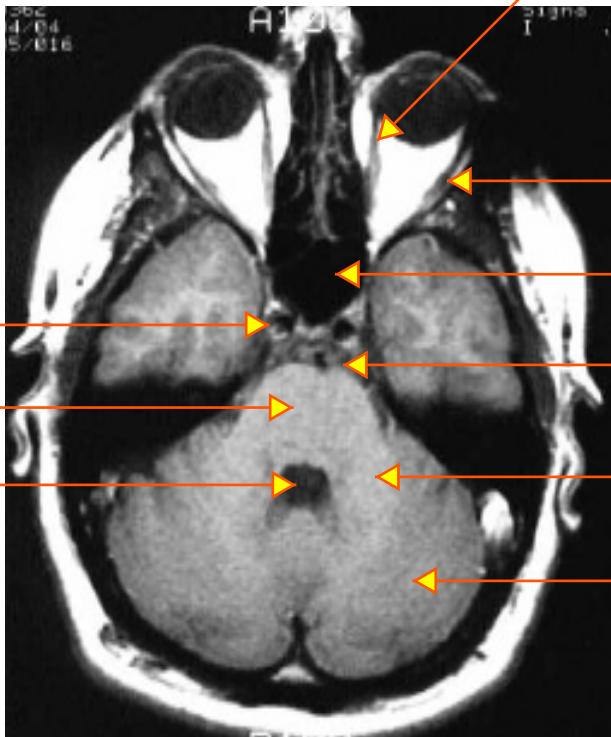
T1 Axial MRI. (From Rand Swenson Dartmouth Medical School)
